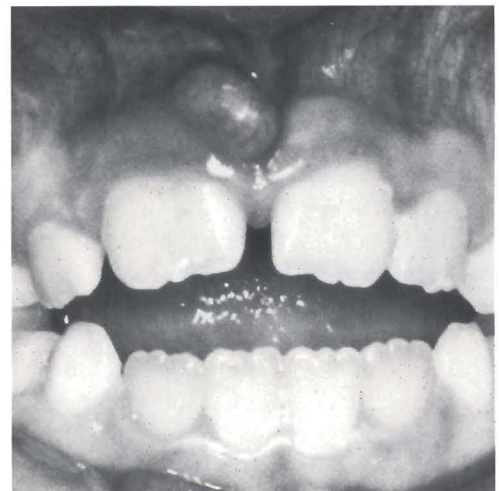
Clinical presentation before treatment. Note evidence of periapical granuloma.
